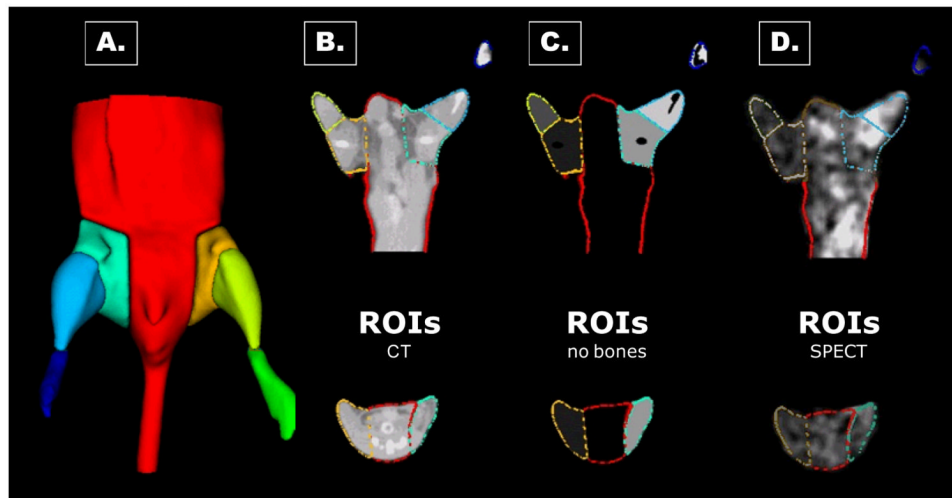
Method for analysis of microSPECT-CT images
